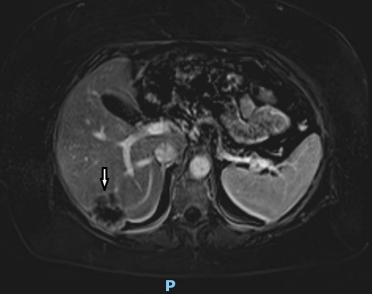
MRI revealing exophytic mass in the liver
